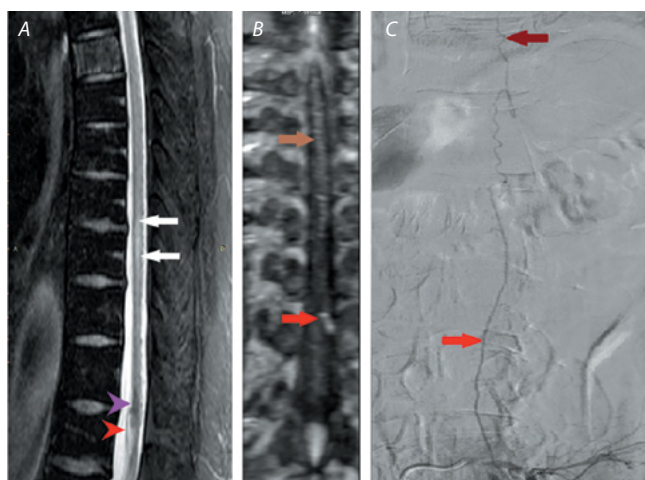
MRI and angiography of patient S. with spinal venous insufficiency at Th8–Th10, Th11–Th12.
